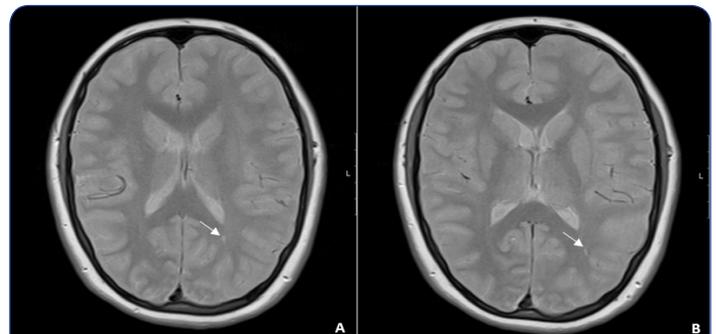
A. and B. Proton Density (PD) weighted MRI of the brain revealed dilatations of the Virchow-Robin spaces. EEG showed slower theta activity.
